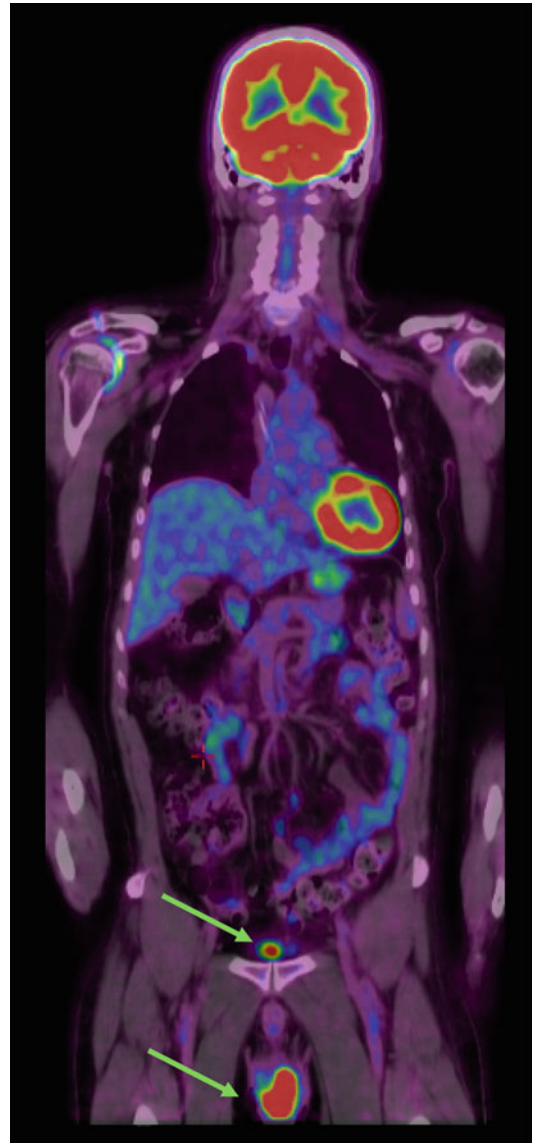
TEP-CT at staging in a man treated for a primary CNS lymphoma, presenting with a testicular relapse 5 months after initial treatment. A 58-year-old man with DLBCL involving the left thalamic region was treated by high-dose methotrexate and cytarabine chemotherapy followed by brain radiotherapy. A complete response was obtained after chemotherapy and radiotherapy. The initial staging was normal. Five months after the end of the treatment, a left testicular mass was discovered by the patient. Orchidectomy revealed a DLBCL. A new staging was performed: PET-CT showed testicular and lombo-aortic lymph node involvement. Brain MRI and bone marrow biopsy were normal. The patient was treated with three courses of the rituximab, carboplatin, ifosfamide, etoposide (R-ICE) regimen followed by high-dose chemotherapy and autologous stem cell transplantation. One year after this treatment, the patient remained in complete response.
